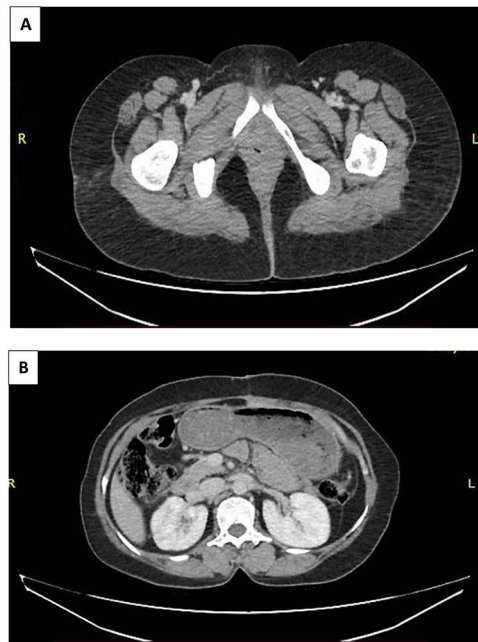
(A and B) Follow-up CT images demonstrating no evidence of recurrence or metastatic disease.
